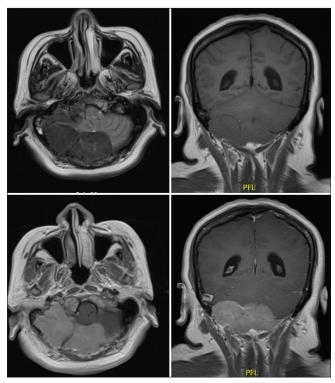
T1-T2-weighted and T1-weighted contrast-enhanced brain MRI of Case 2. There is widening of the cancellous bone of the occipital squama and the petrous bone.
